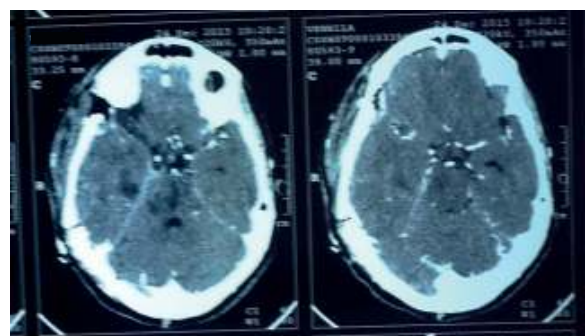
Immediate post op CT after second stage showing no residual lesion
